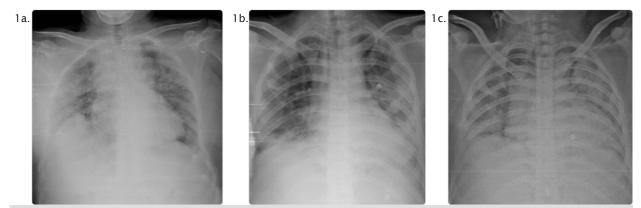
Chest X-ray in different patients showing: a. interstitial and ground glass opacity in B/L lungs. b. Groundglass opacity in B/L lungs c. B/L lung consolidations.
